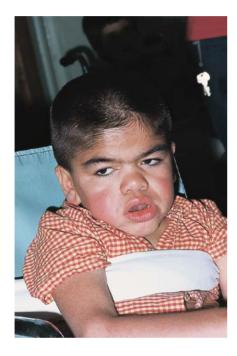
CT: A patient with Hunter syndrome. In this most severe form of the disease, the features are quite coarse, the lips very thick, hirsutism prominent, and the hands claw-like, as in Hurler disease. The corneas were clear.
